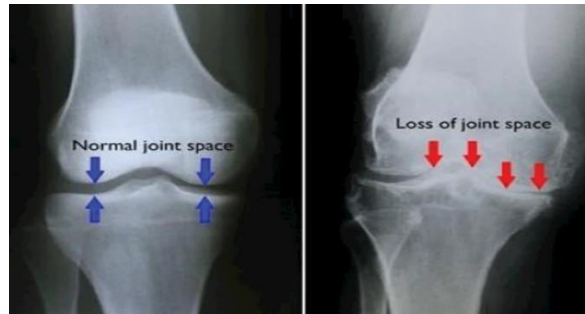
Pictorial representation of the X-ray image of human normal knee joint and OA joint
